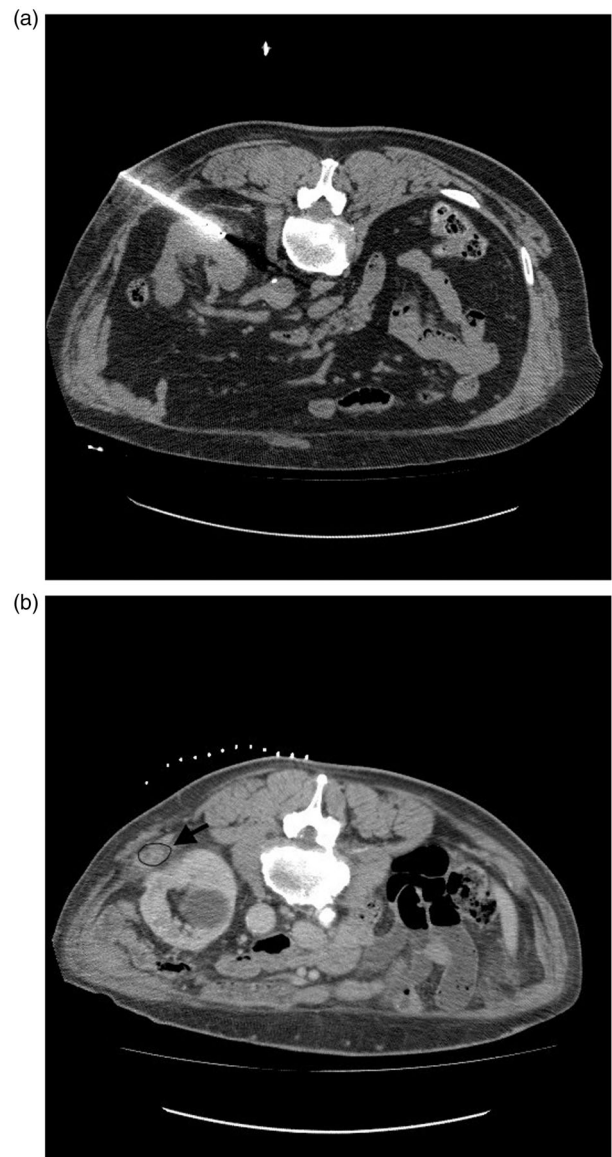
(a) Case 1. CT scan during renal cryoablation showing the probe passed through the right flank. Patient was placed in prone position during the procedure. (b) Case 1. RMN at 12 months after percutaneous cryoablation demonstrating a recurrent tumour mass in the right flank musculature along the the cryoprobe tracts. The mass was biopsied with evidence of undifferentiated renal cell carcinoma.
